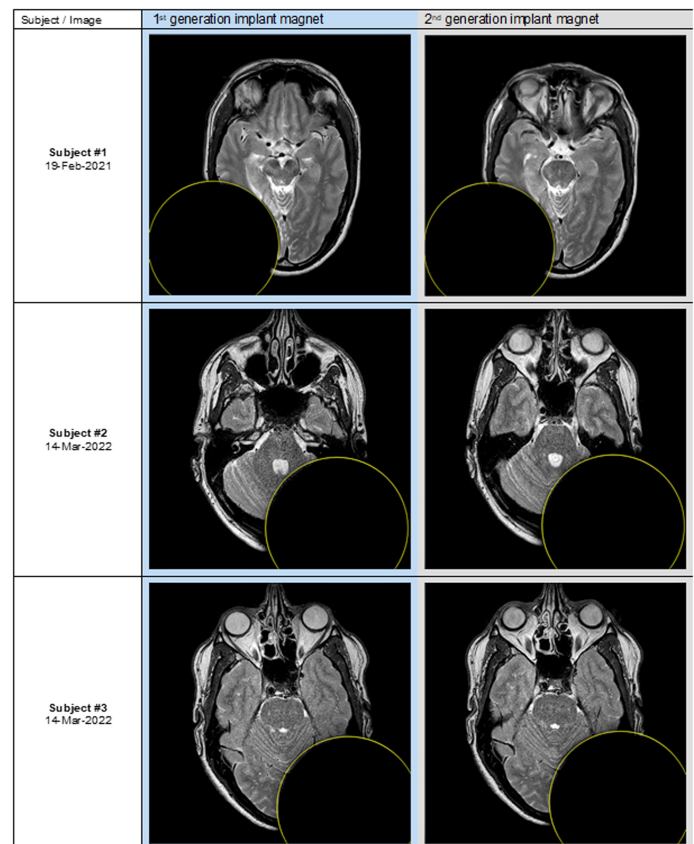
Intraindividual comparison of maximum image artifact size in 3T MRI T2W TSE images for 3 subjects with cochlear implants with both first- and second-generation implant magnets fully circumscribed by a circle of 125 mm in diameter.
